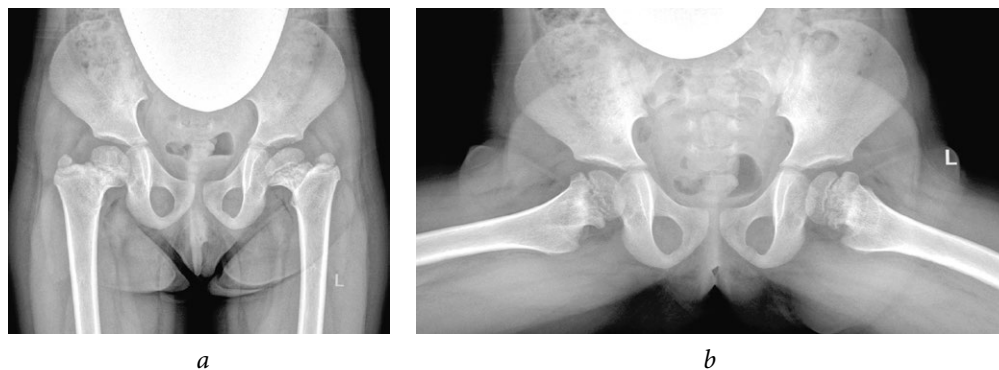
Radiographs of patient G. at the age of 4 years: frontal view (a) and Lauenstein view (b). The emerging high position of the greater trochanter on both sides and dystrophic changes in the femoral neck are visible. A radiograph taken when the patient was 3 years of age had shown manifestations of transient synovitis of the hip joints after an acute respiratory viral infection
